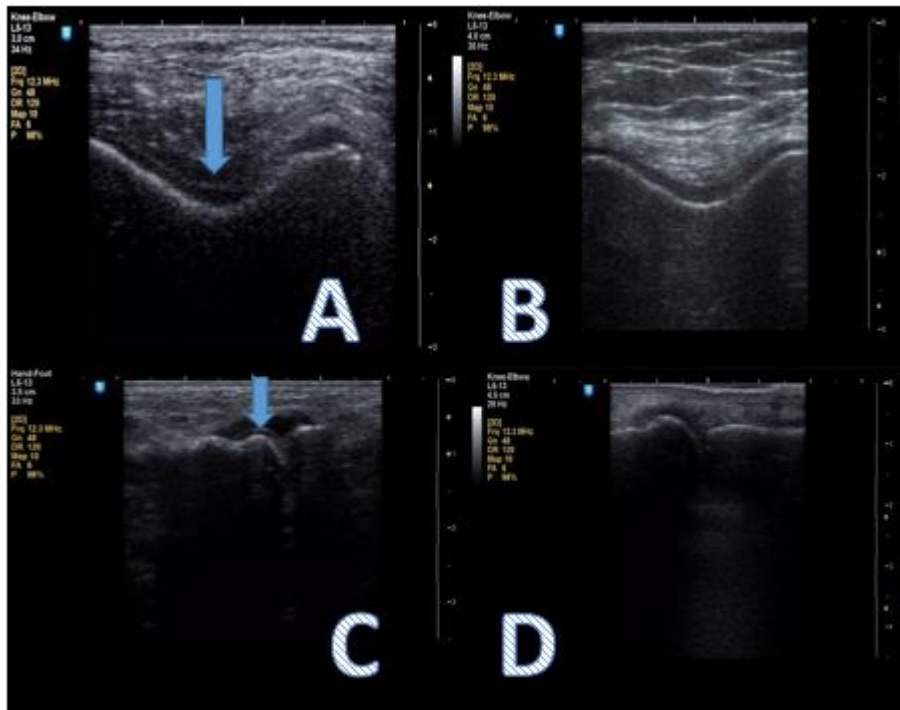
Ultrasonographic findings of the knee (transverse suprapatellar view of the femoral cartilage in maximal flexion) and 1st MTP (longitudinal dorsal view) joints before and after treatment.
